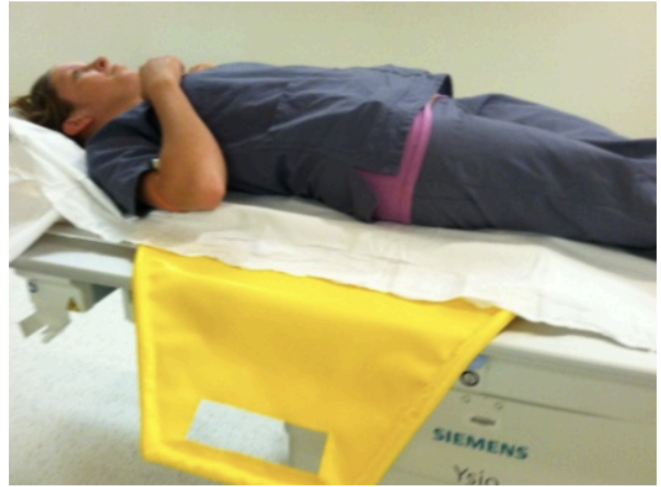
Current design during a demonstration of its placement. When placed, the board is seen providing a hard surface to raise the patient out of the hospital bed. This provides a clearer line of sight for portable X-ray hardware.
